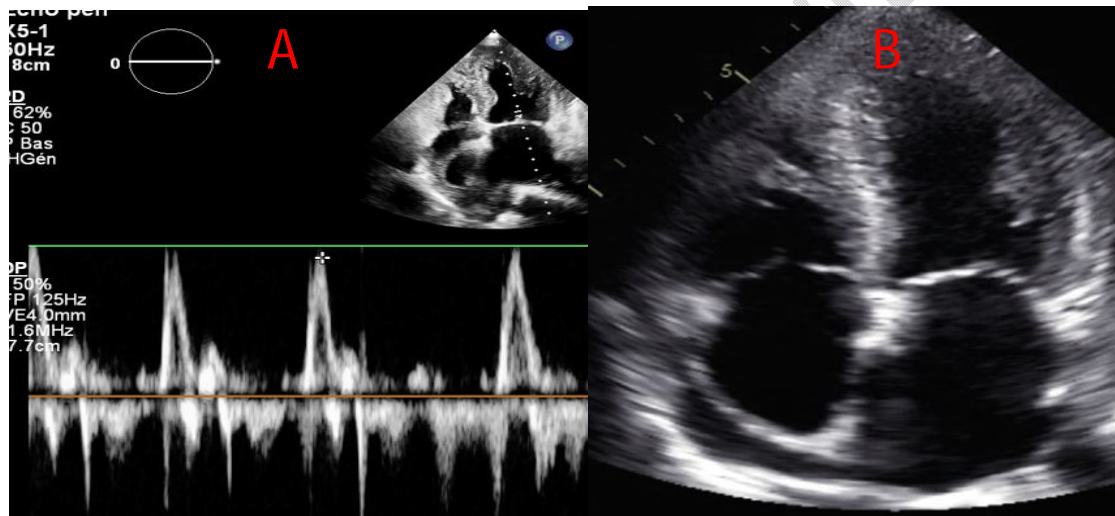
Trans thoracic echocardiography (TTE): A – Continuous wave Doppler at the junction of the mitral valve showing a restrictive mitral flow. B-4 chambers apical view showing minimal pericardial effusion of the lateral wall of the right atrium.
